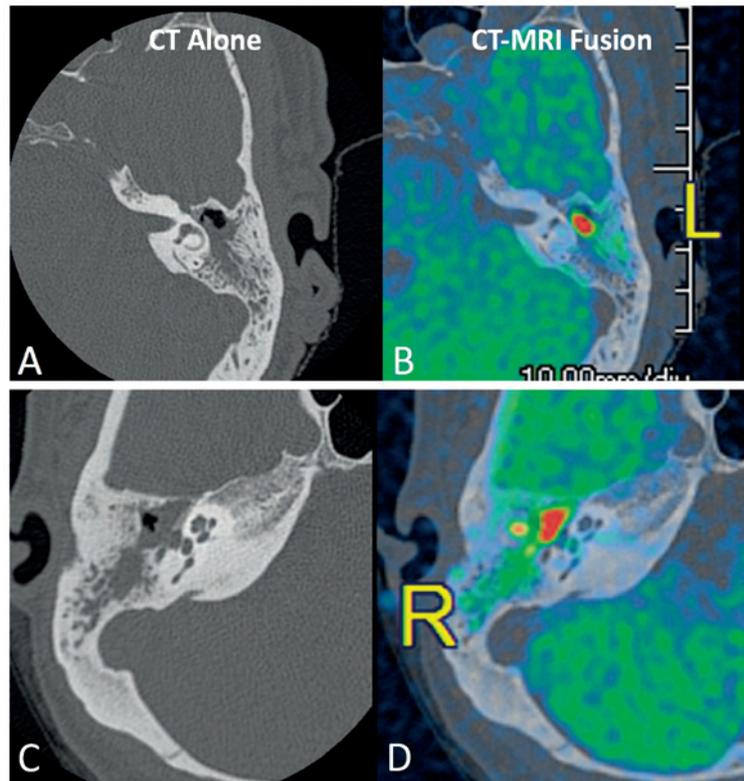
Two separate examples of cases where the CT scan demonstrated complete opacification of the mastoid cavity but CT-MRI Fusion imaging revealed that the cholesteatoma was limited to the middle ear. Images B and D show the fused CT-MRI images related to the plain CT images A and C, respectively.
